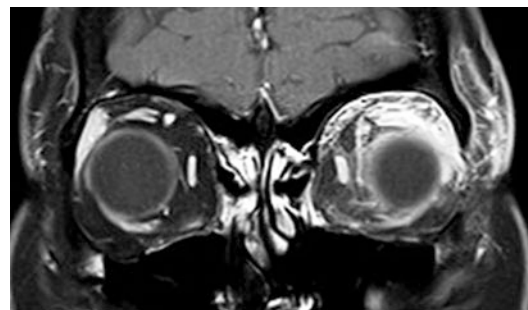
Coronal MRI showing infiltrative lesion of the left lacrimal gland
